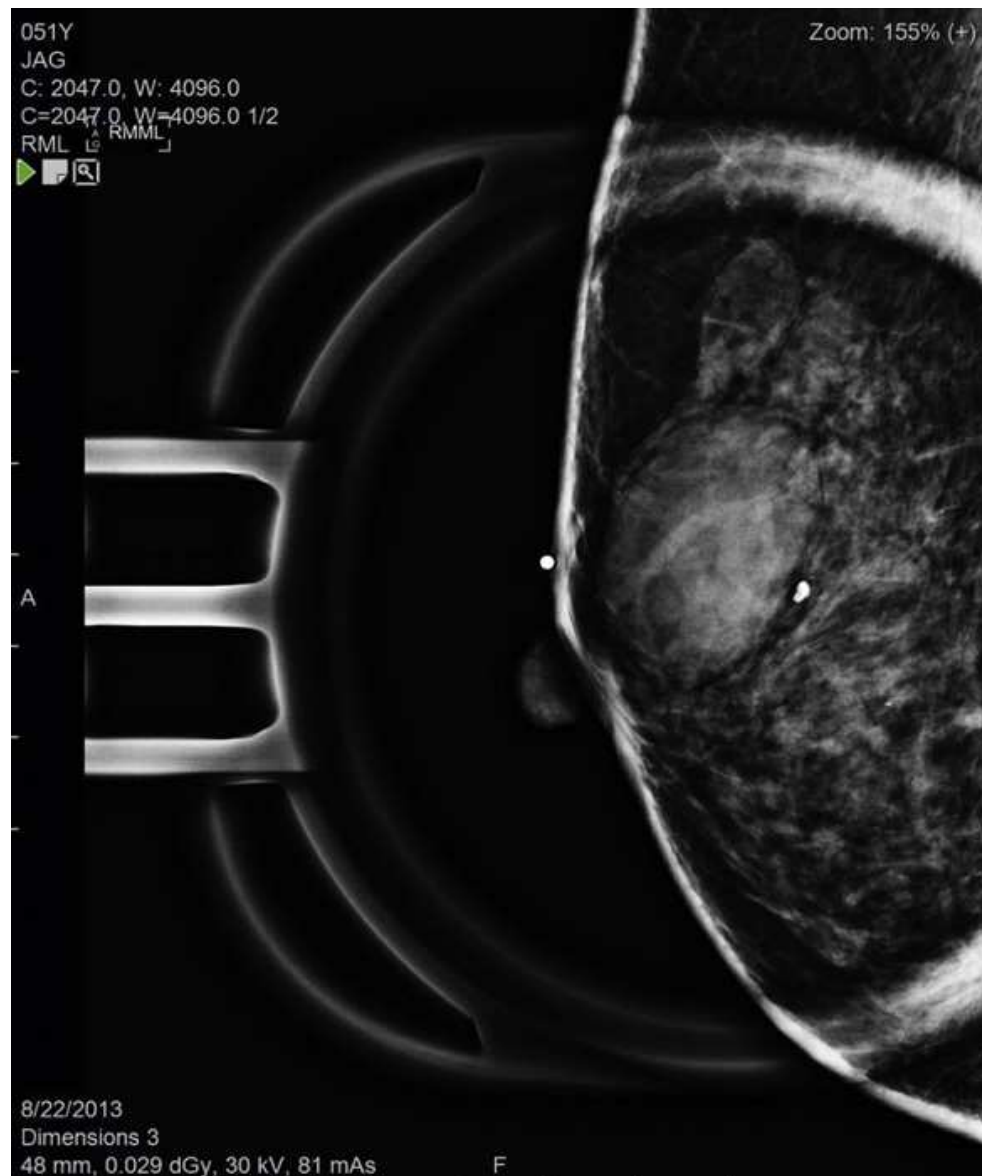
Right MLO projection using the magnification technique and a spot paddle to perform a tangential view of a palpable mass. This proved that the mass was smoothly outlined with uniform edges and was shown to be a cyst on ultrasound.
